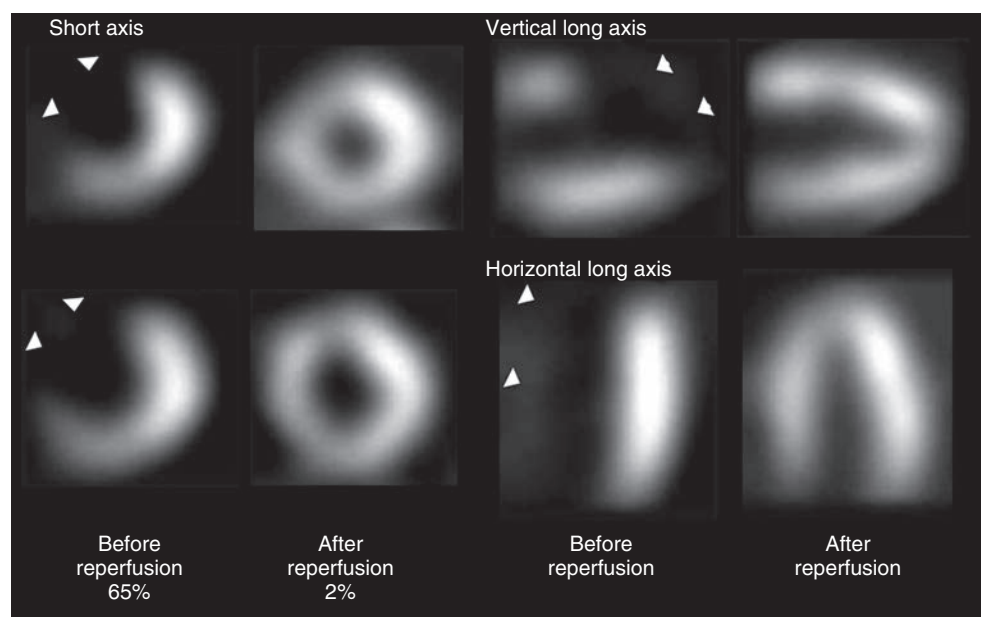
Representative short, vertical long-axis, and horizontal long-axis images obtained with ^{99m}Tc-sestamibi single positron emission computed tomography (SPECT) in a patient with anterior myocardial infarction. The initial sestamibi injection image (obtained before reperfusion) shows a large and severe perfusion defect (arrowheads) throughout the left anterior descending artery (LAD) territory, reflecting the total territory of myocardium at risk. Image obtained after a second dose of sestamibi a week later reflects the final infarct size (arrowheads) after reperfusion. The percentage difference between the initial and final images reflects the magnitude of salvaged myocardium after reperfusion. (Courtesy of Dr. Todd Miller, Mayo Clinic, Rochester, Minnesota.)
